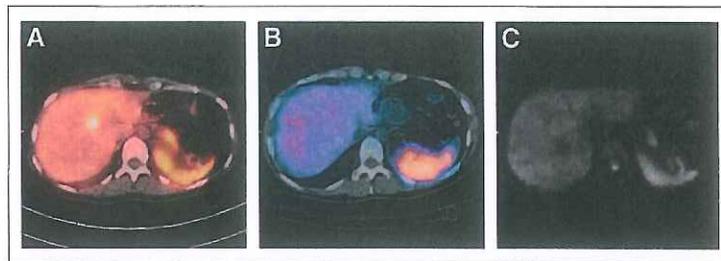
A 34-y-old woman with bronchial NET who underwent all 3 studies to evaluate response after chemotherapy. Patient had multiple liver lesions with marked uptake before chemotherapy. After chemotherapy, ^{68}Ga -DOTATATE PET/CT (A) demonstrated marked uptake in one remaining liver metastasis, indicating lack of complete response to treatment, whereas SSRS SPECT/CT (B) and WB DWI (C) did not identify this lesion.
